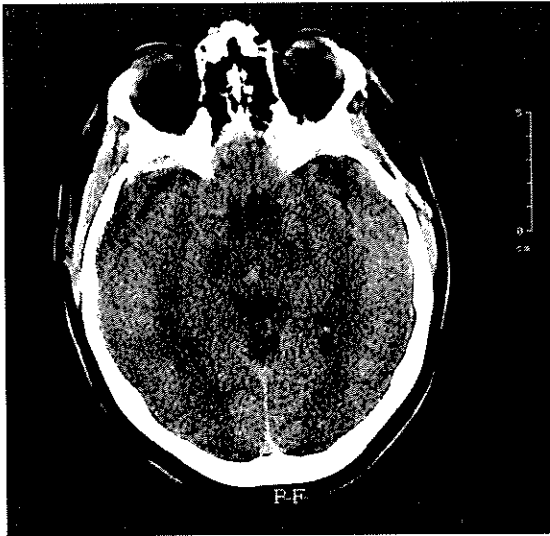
Transverse section of CT scan taken 2 weeks post-trauma
